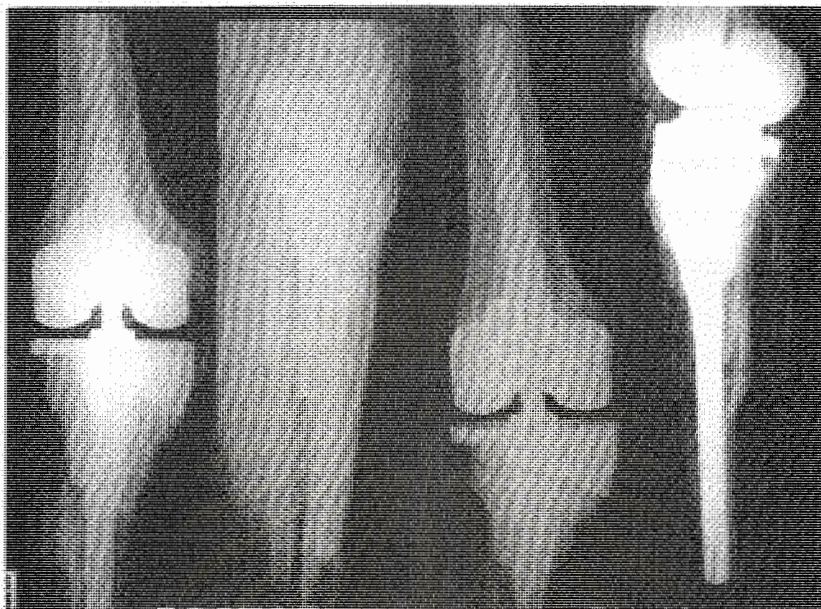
Immediate postoperative radiographs of the first patient compared with 14-month postoperative radiographs reveal that the prosthesis is still well fixed without radiolucency line.
